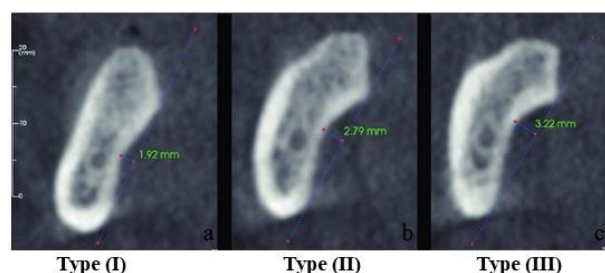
Submandibular fossa types based on depth in cross-sectional sections in CBCT images
